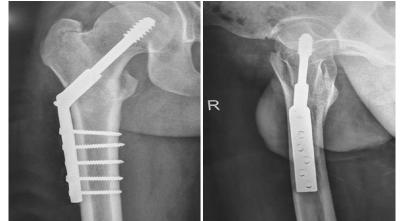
Plain radiograph showing anterior and posterior lateral views of right hip showing the trochanteric fracture after 3 months postoperatively of fixation by DHS. DHS, dynamic hip screw. (28) Surgical technique:
